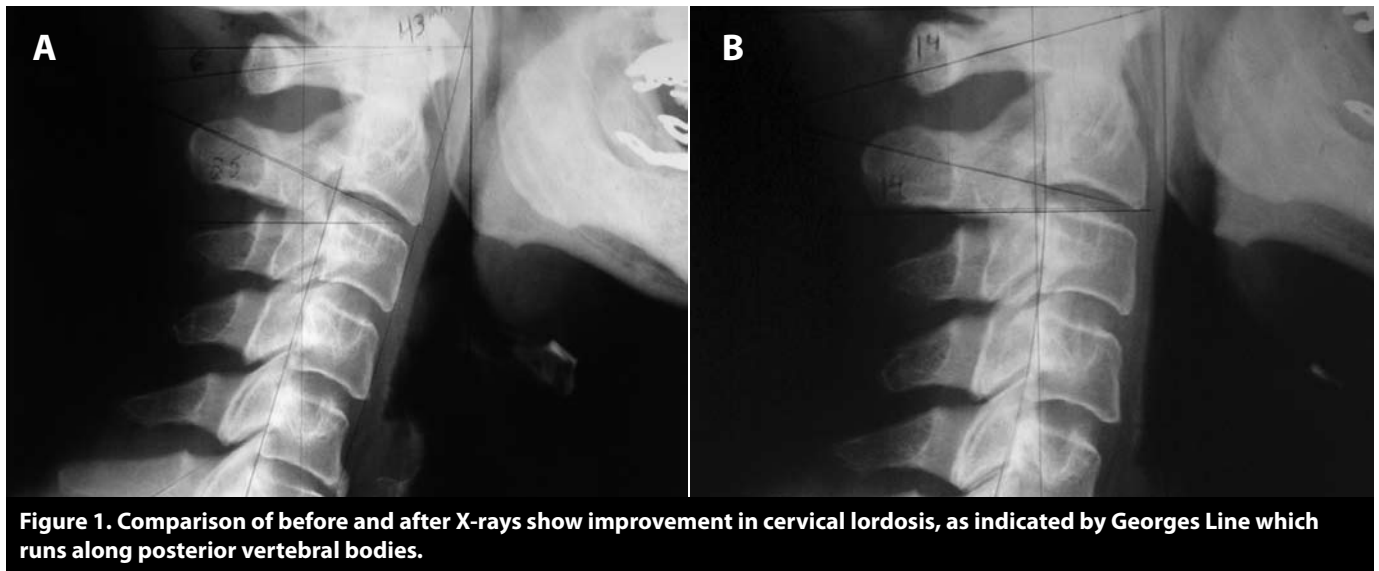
Comparison of before and after X-rays show improvement in cervical lordosis, as indicated by Georges Line which runs along posterior vertebral bodies.
